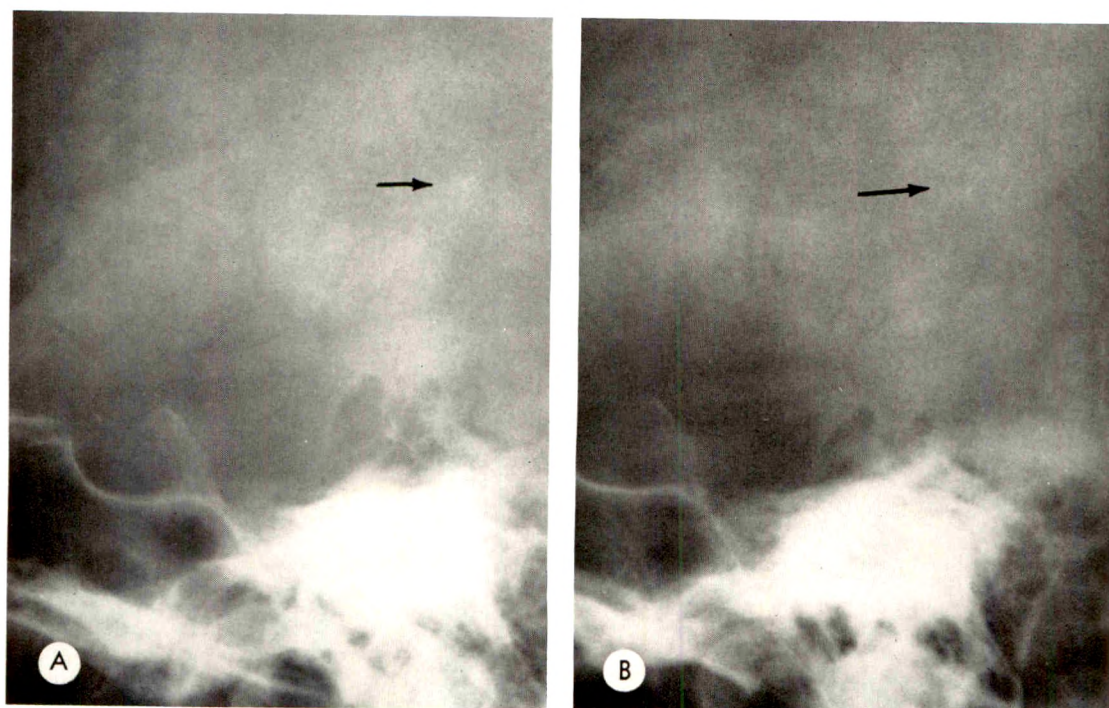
(*A* and *B*) Stereoscopic lateral skull roentgenograms showing different appearances of the habenular calcification.
